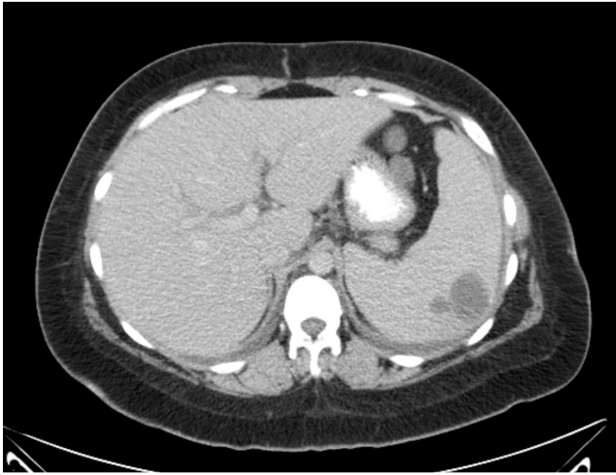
Postpartum Day #31, CT scan showing a splenic lesion
